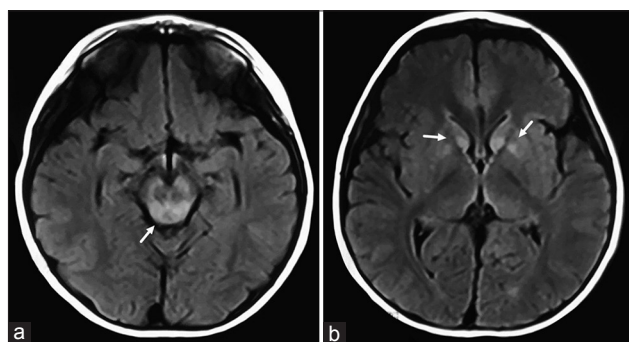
Brain MRI of patient no. 11. T2WI-FLAIR (a and b) showed hyperintensity in the midbrain and basal ganglia. MRI: Magnetic resonance imaging; T2WI: T2-weighted images.
